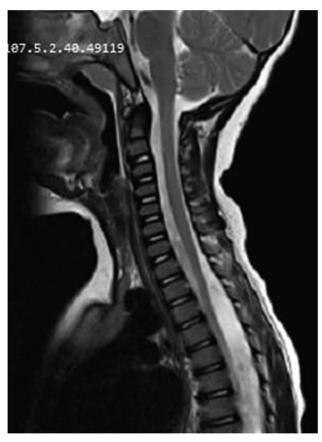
Sagittal T2-weighted MRI reveals diffuse edema and abnormal signal between the medulla and the fifth cervical vertebra.
